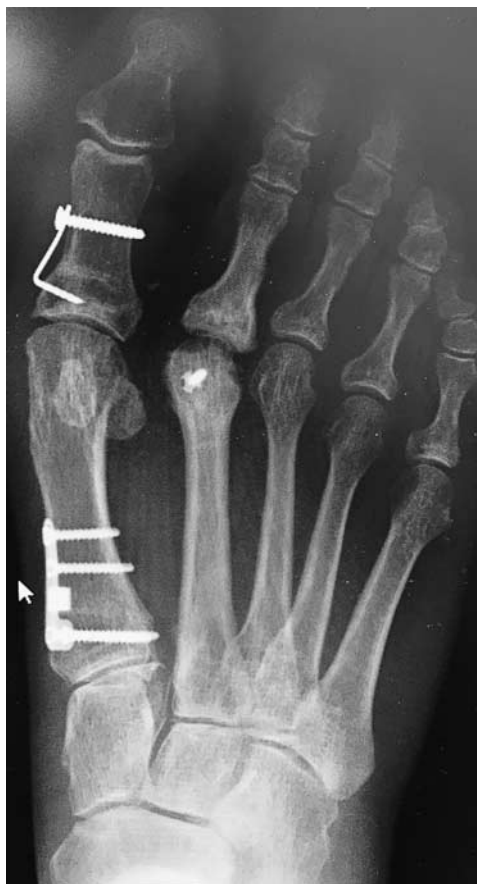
Anteroposterior radiograph showing a failure of proximal opening wedge osteotomy at 1.5 years postoperatively. Note the recurrence of hallux valgus and encroachment on the second toe requiring a revision.
